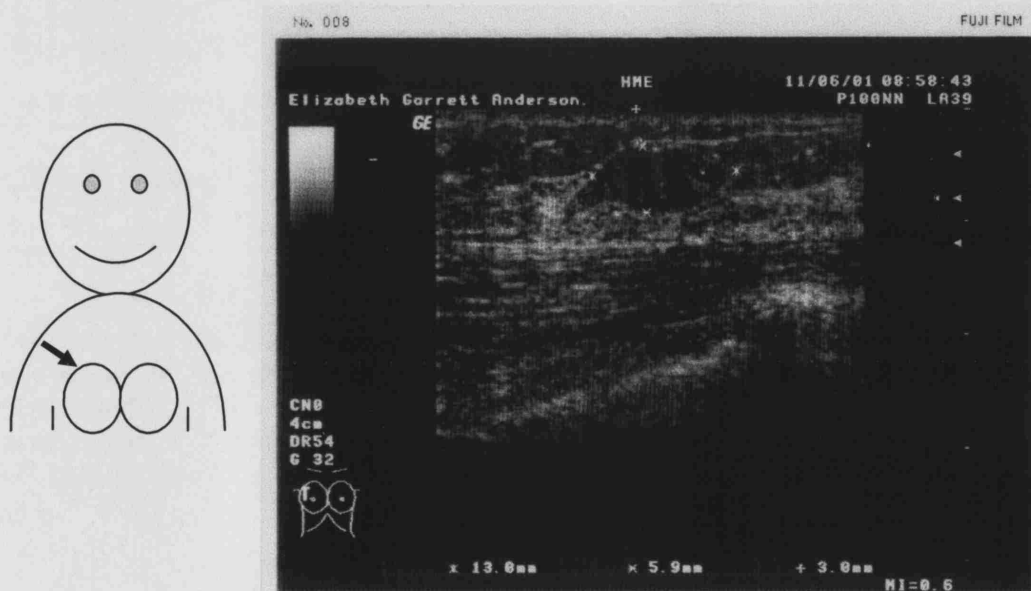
An indication of the position of the fibroadenoma and the ultrasound image of the fibroadenoma.
